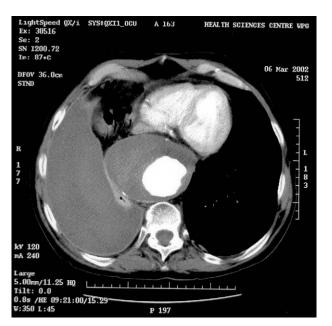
CT taken preoperatively at the level of the interventricular septum showing the aneurysm 10 cm in transverse diameter with a right hemothorax.
